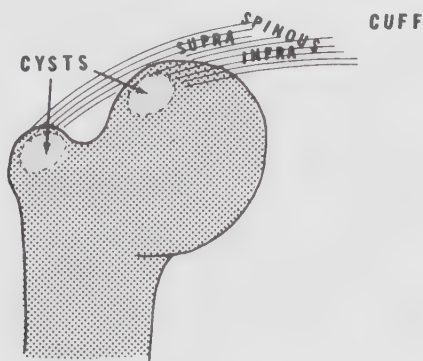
Roentgenographic changes in shoulder dysfunction: cysts in the tuberosities of the humerus. These are early x-ray evidence of attrition. With wear and tear, the tuberosities become eroded, causing a volcano appearance. The bicipital groove becomes shallow.
